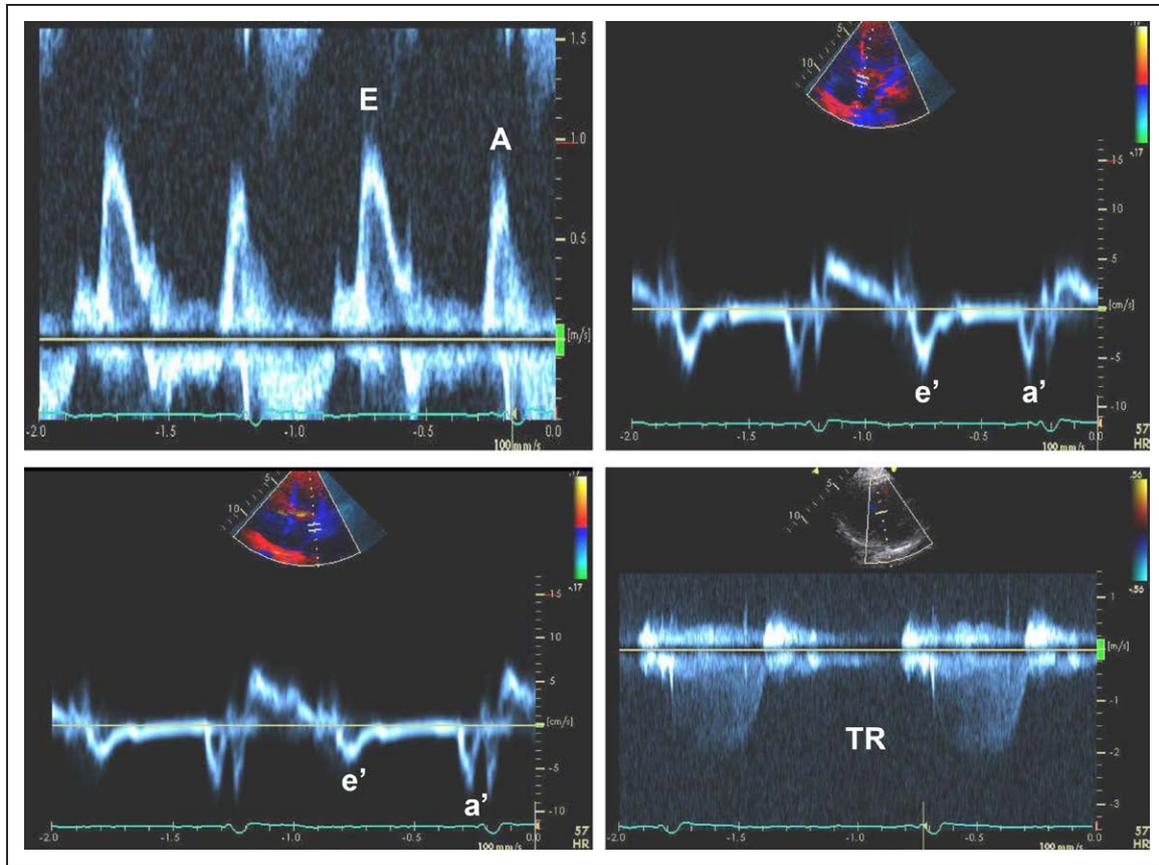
Mitral inflow (upper left), septal tissue Doppler (TD) velocities (upper right), lateral TD velocities (lower left), and peak tricuspid regurgitation (TR) velocity (lower right) from an 81-y-old woman with history of hypertension.
